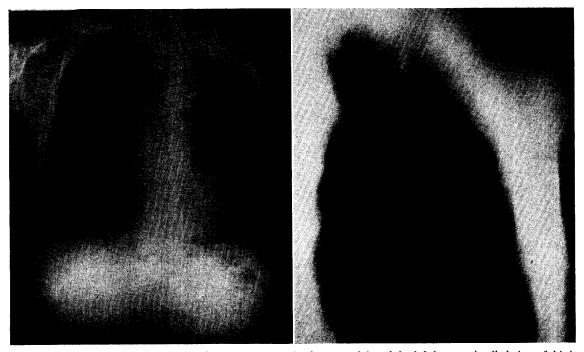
Case VIII. Two roentgenograms show a mycetoma in the upper lobe of the left lung; a detailed view of this is shown in the planigram which reveals the crescentic radiolucency surrounding the fungus ball.
